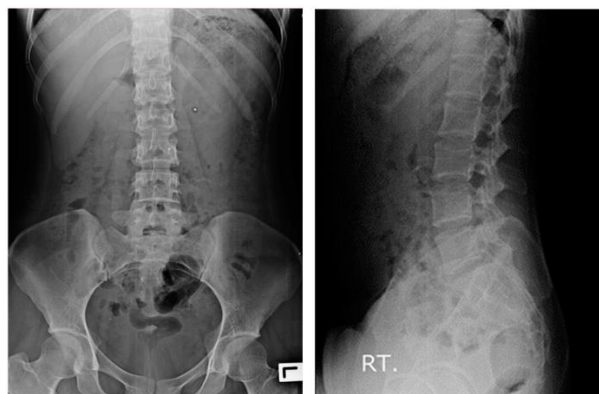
PREOPERATIVE XRAY AP AND LATERAL VIEW
